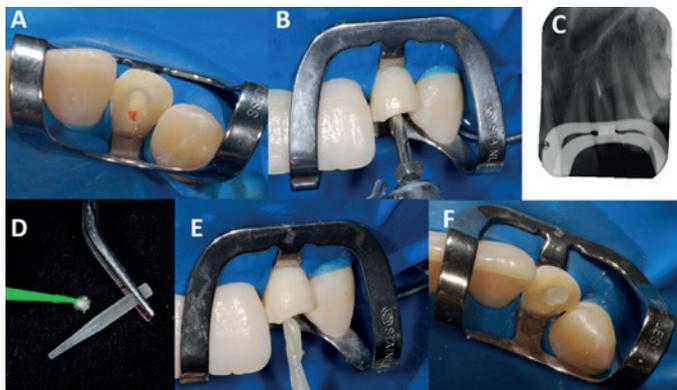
Post luting procedure. (A) Rubber dam isolation; (B) Post space preparation; (C) Radiographic image of the root filling remaining at the apex (4.0 mm); (D) Surface treatment of the post; (E) Post luting; (F) Post luting procedure finalized.
